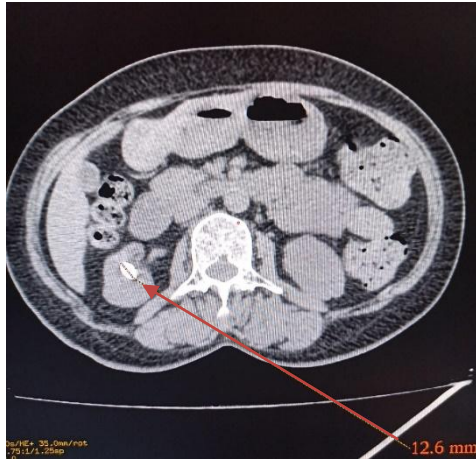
CT KUB axial view and 1-b CT KUB coronal view showing calculus in lower pole of right kidney.
